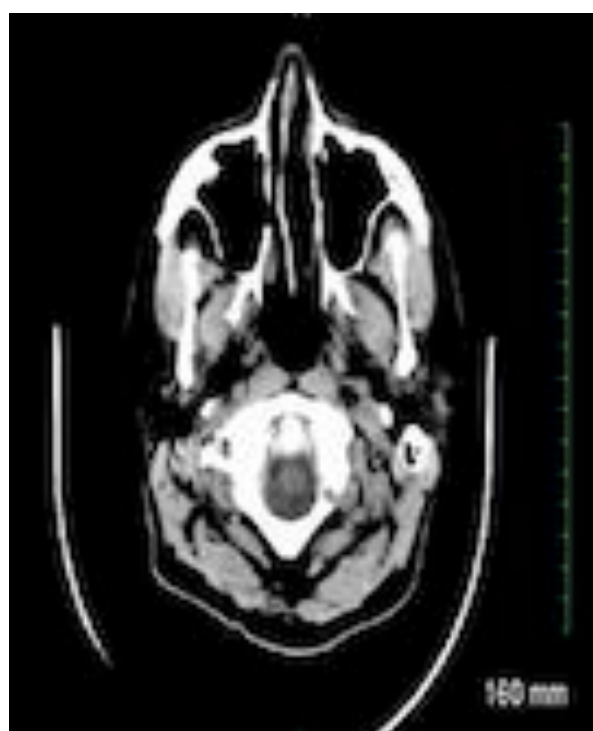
CT-scan of the Brain: No acute intracranial hemorrhage, herniation or hydrocephalus.
